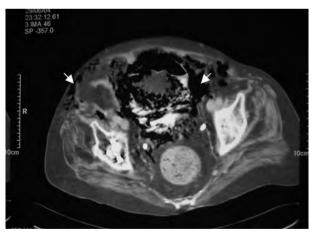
Abdominal-pelvic computerised tomography (CT) demonstrating air in the vesical wall with extension to the perivesical space, right periurethra and retroperitoneum (arrows).
